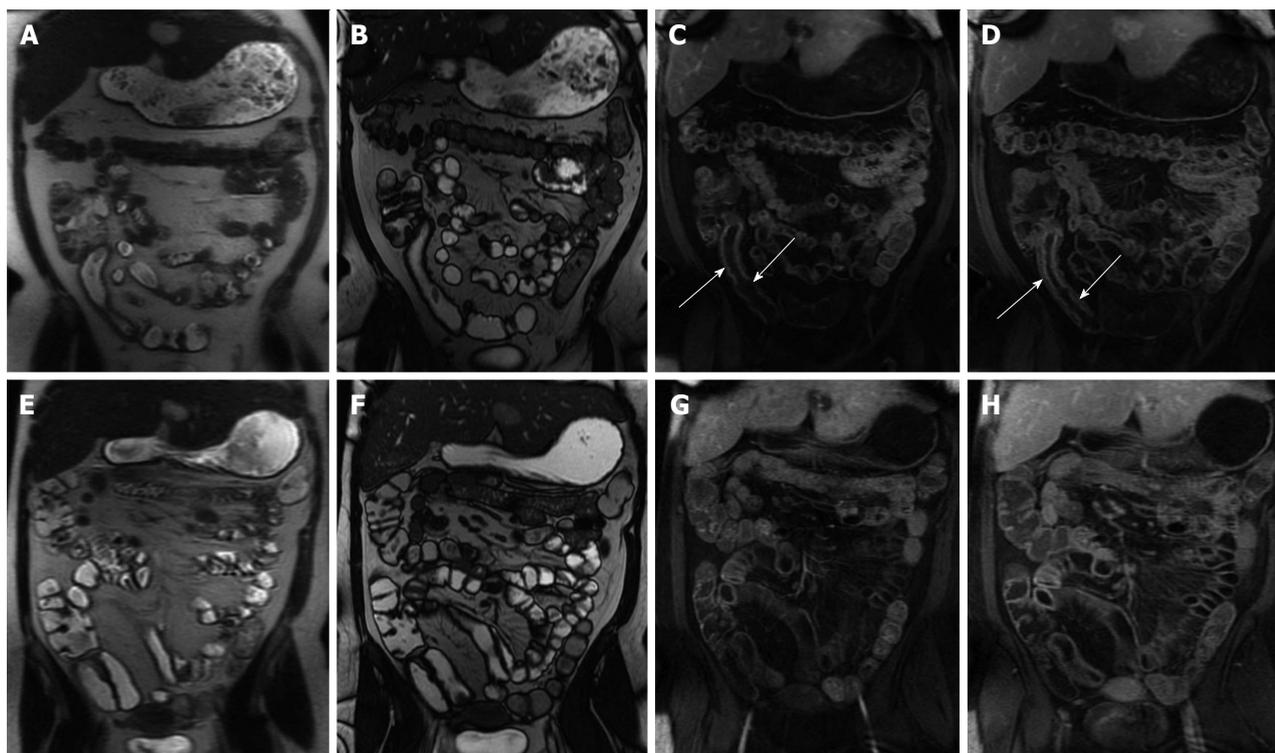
Imaging followup in a patient with Crohn's disease. A and E: Coronal T2-weighted single shot fast spin echo; B and F: Coronal balanced steady state free precession images; C and G: Coronal; D and H: Axial fat-suppressed post-gadolinium 3D-GRE T1-weighted images. There is evidence of active Crohn's disease involving a long segment of the terminal ileum (A, B, C and D) in form of diffuse wall thickening and submucosal mucosal enhancement (arrows, C and D). Four-month re-evaluation shows interval decreased wall thickening and significant decreased mucosal/serosal enhancement, consistent with favourable response to medical therapy. GRE: Gradient recalled echo.
